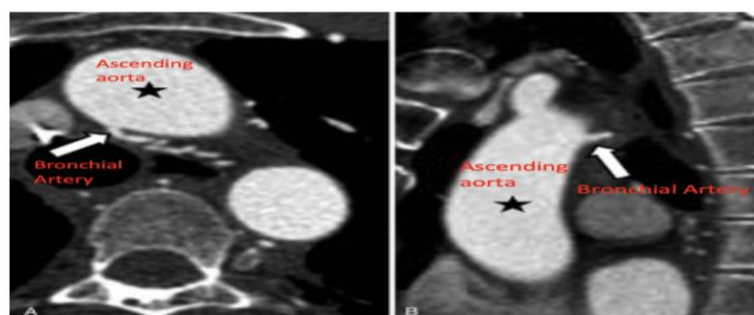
Ectopic bronchial artery from ascending aorta. (A, B) Chest CT shows common trunk of bronchial artery (white arrow) originates from ascending aorta (star).
